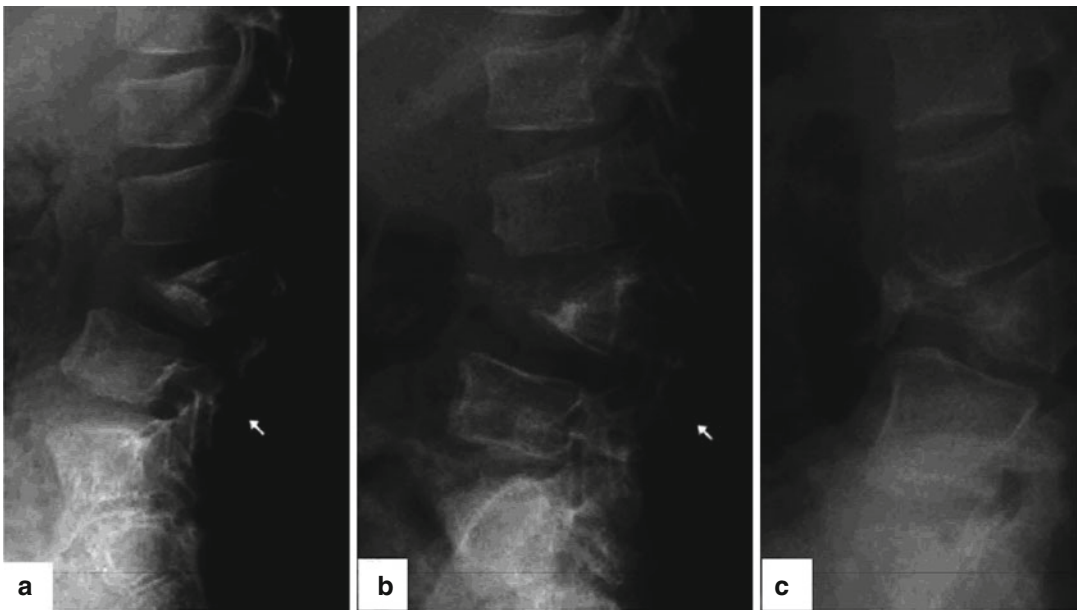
Type B restabilization. Type B healing is seen when the vertebral body loss is between 1 and 1.5. (a) Lateral radiograph of the lumbar spine shows significant destruction following L3-4 spondylodiscitis which has resulted in local kyphosis. (b, c) Lateral radiographs performed at 60 and 180
